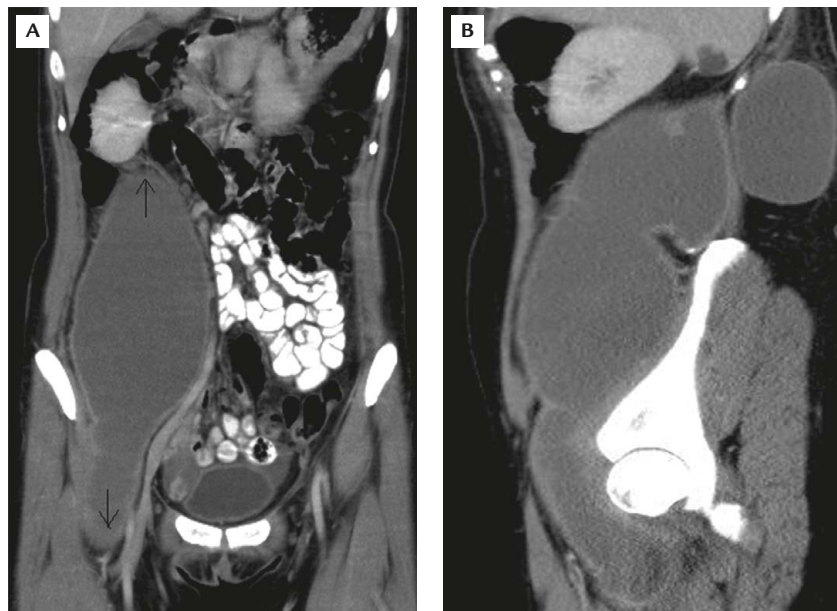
(A) Coronal and (B) sagittal planes of the abdominal computed tomography. Two large communicating retroperitoneal cysts extending from the right flank subcutaneous region to the right groin.
